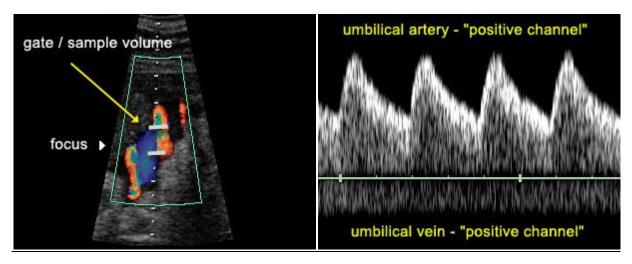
Umbilical cord displaying umbilical artery (red) and umbilical vein (blue), the gate or sample volume include both signals (left). Sonogram of the umbilical artery and vein (right). Guidelines for a practical approach to obtain good-quality spectral images are given in Table 2.5.
